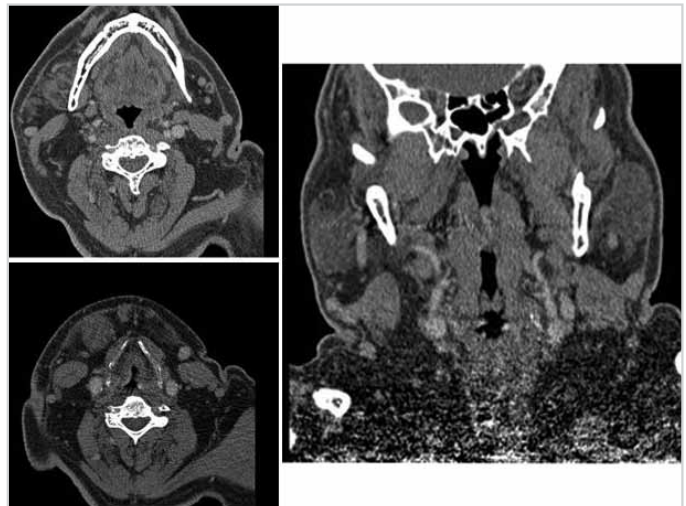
CT images of patient in fifth year after primary radiotherapy during routine follow up
